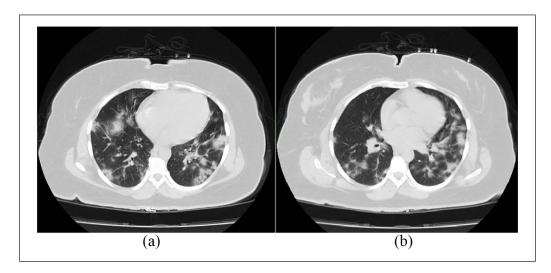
Lung high-resolution computed tomography compatible with Severe Acute Respiratory Syndrome Coronavirus 2 pneumonia (a and b).
